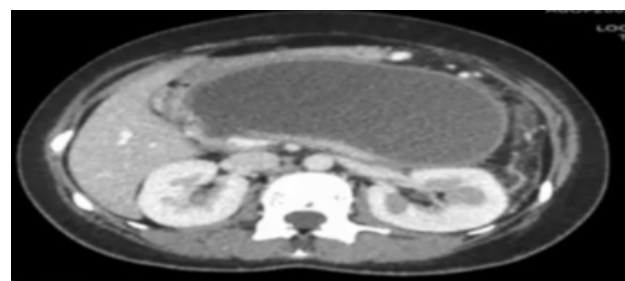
CT abdomen of large pancreatic pseudocyst. CT, computed tomography.
